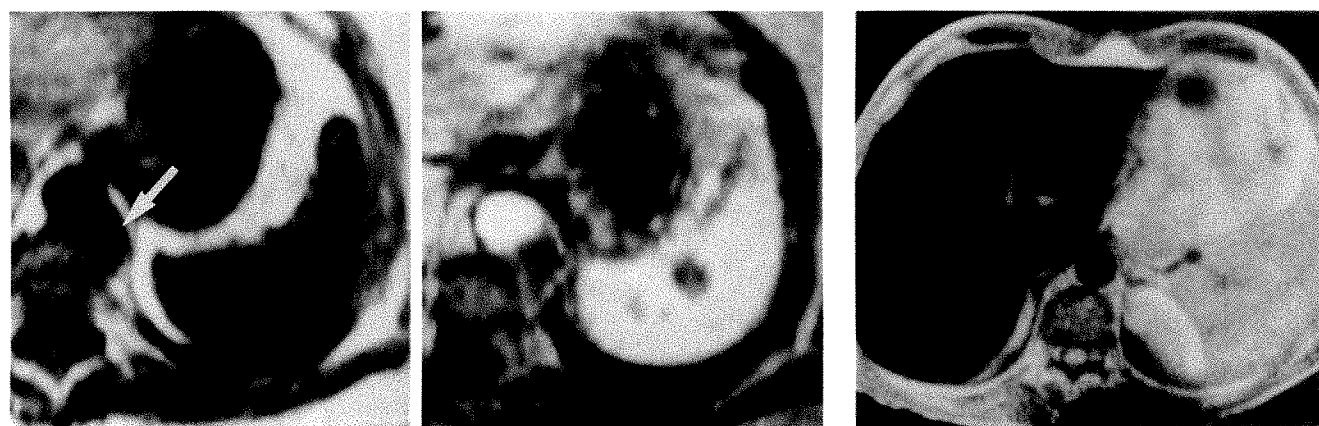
Dynamic gadopentetate dimeglumine-enhanced MR imaging at 1.5 T, GRE 100/5, 80°.
